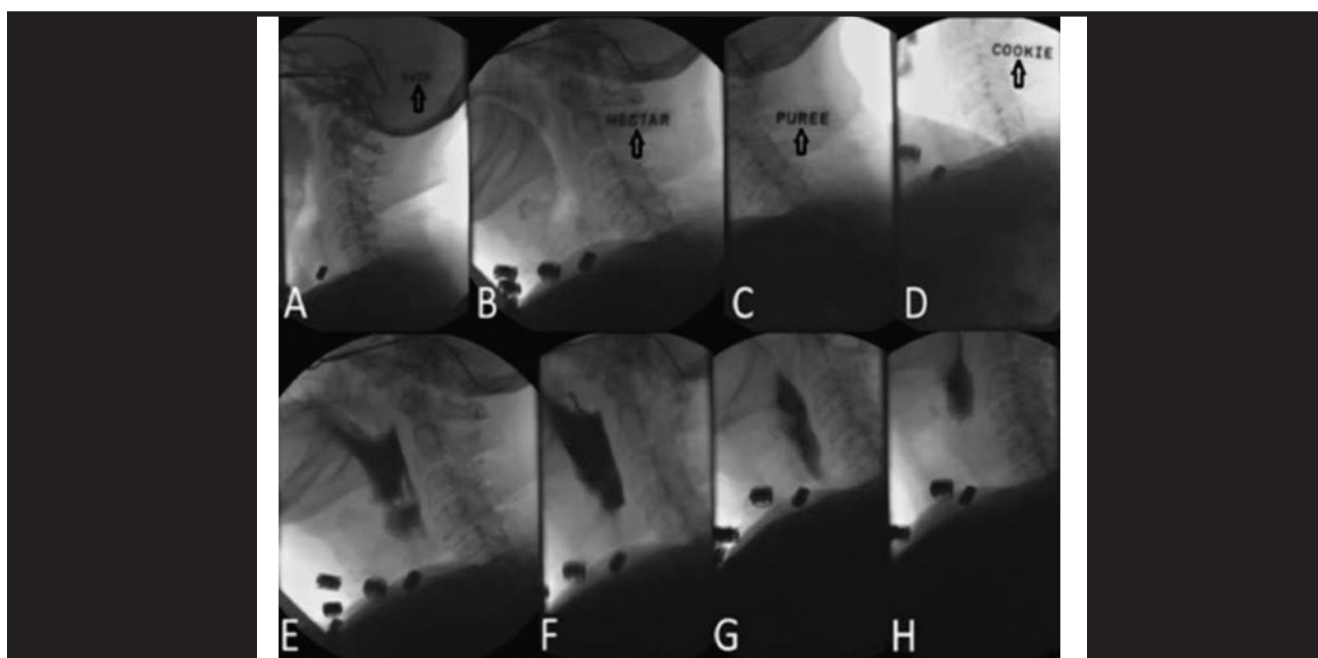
Radiographic Labels in Clinical Practice
